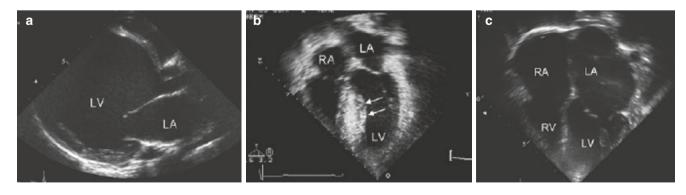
Echocardiographic findings of pediatric cardiomyopathies. (a) Parasternal long-axis view demonstrates severe left ventricular dilation in a child with idiopathic DCM. (b) Asymmetric septal hypertrophy (arrows) in a child with HCM. (c) Apical four-chamber view
